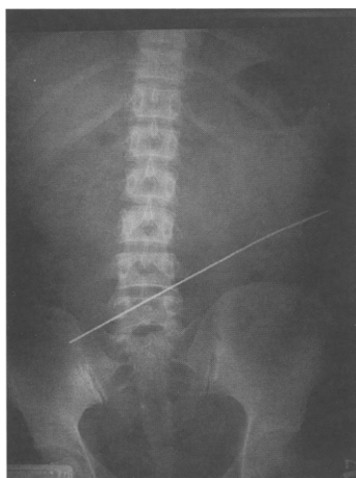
Case 1. A long K-wire in the abdominal cavity, seen on plain abdominal radiograph.
